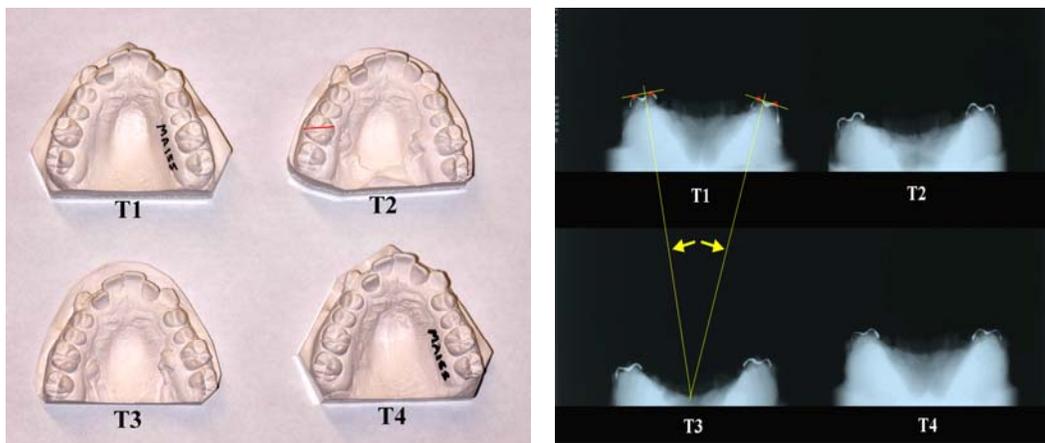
Left:* Casts for subject 37 with barium sulfate painted over the mesiopalatal and distobuccal cusp tips of upper first molars (red line on T2 cast runs through the barium sulfate line) / *Right:* Radiograph of the same casts with the IMT analysis shown for the T1 cast (arrows indicate the angle of interest)
